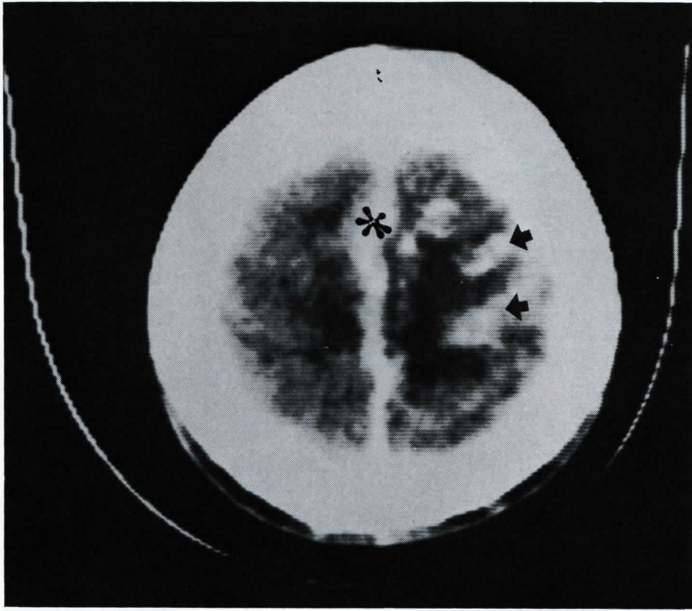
Enhanced CT scan indicating large hypodense area with intense gyral (arrows) and falx (asterisk) enhancement.
